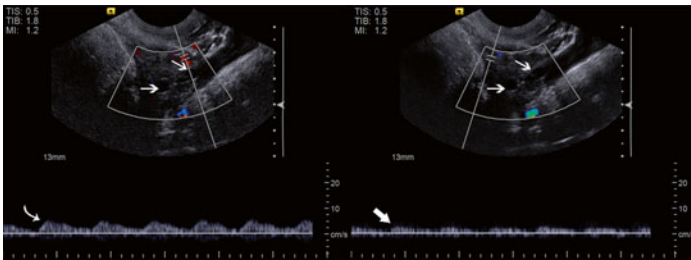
Sagittal Doppler US of the ovary demonstrating normal arterial waveform on the left; normal venous waveform on the right. Morphologically, typical ovaries are of homogenous echotexture with hypochoic follicles (*white arrows*) scattered throughout. Normal ovarian size varies significantly from patient to patient, and asymmetry between the left and right ovaries is often more diagnostically useful. Arterial waveform (*curved white arrow*) should have rapid systolic rise and gradual diastolic fall without inversion below the baseline. Likewise, venous flow (*large white arrow*) should remain uniform without inversion below the baseline.
